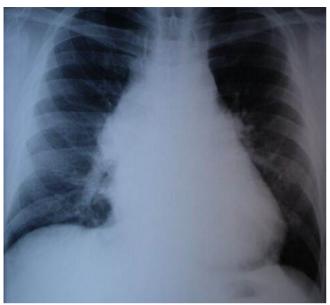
Postero-anterior chest radiography showing mediastinal widening.
